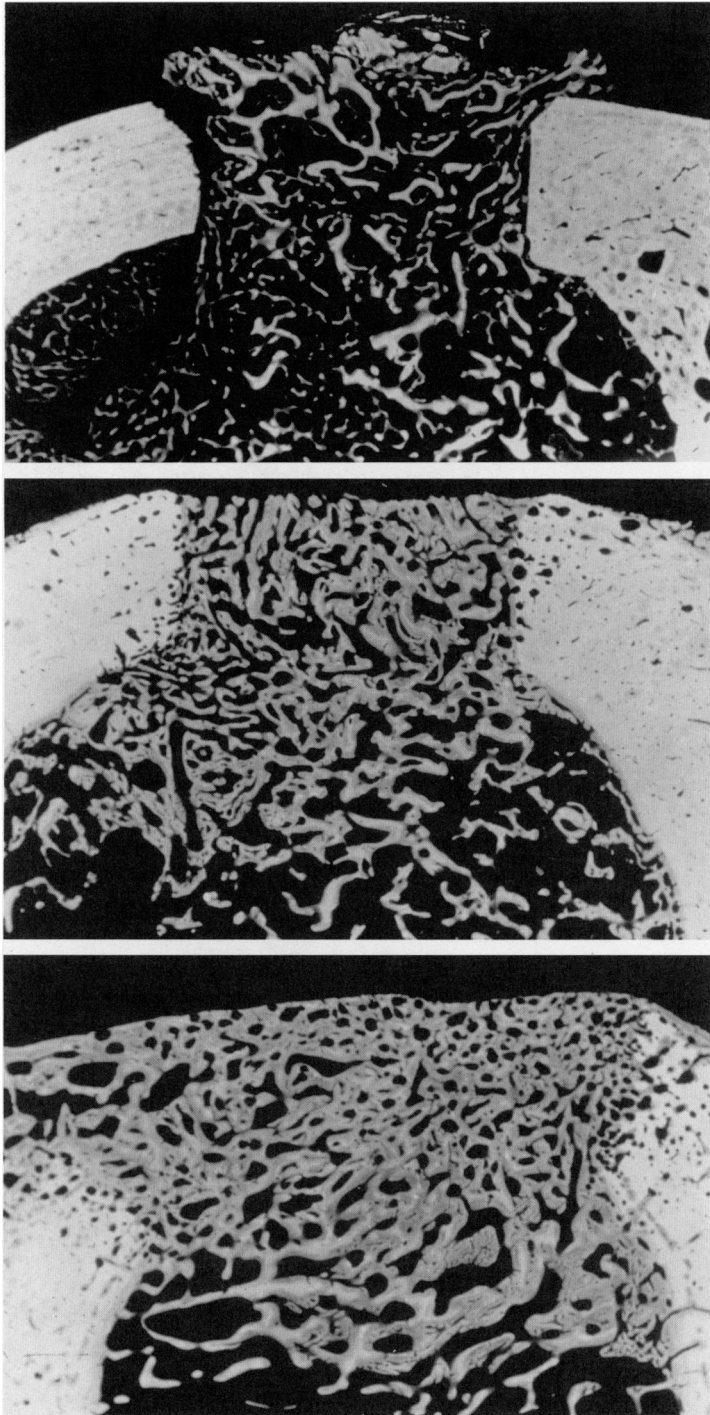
(A, B, and C). Micro-radiographs depict variations of the bone mineral density both within the graft material and at the adjacent intact cortical bone during the healing process at the same time intervals.
